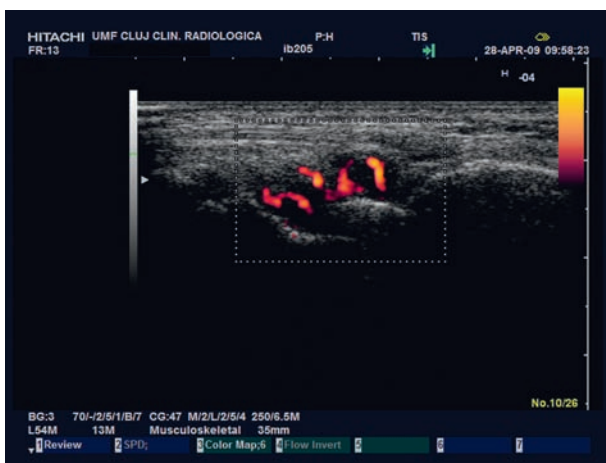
Power Doppler US: F, 42 years, proliferated synovial vascularity in the left third MCP joint, score 3
